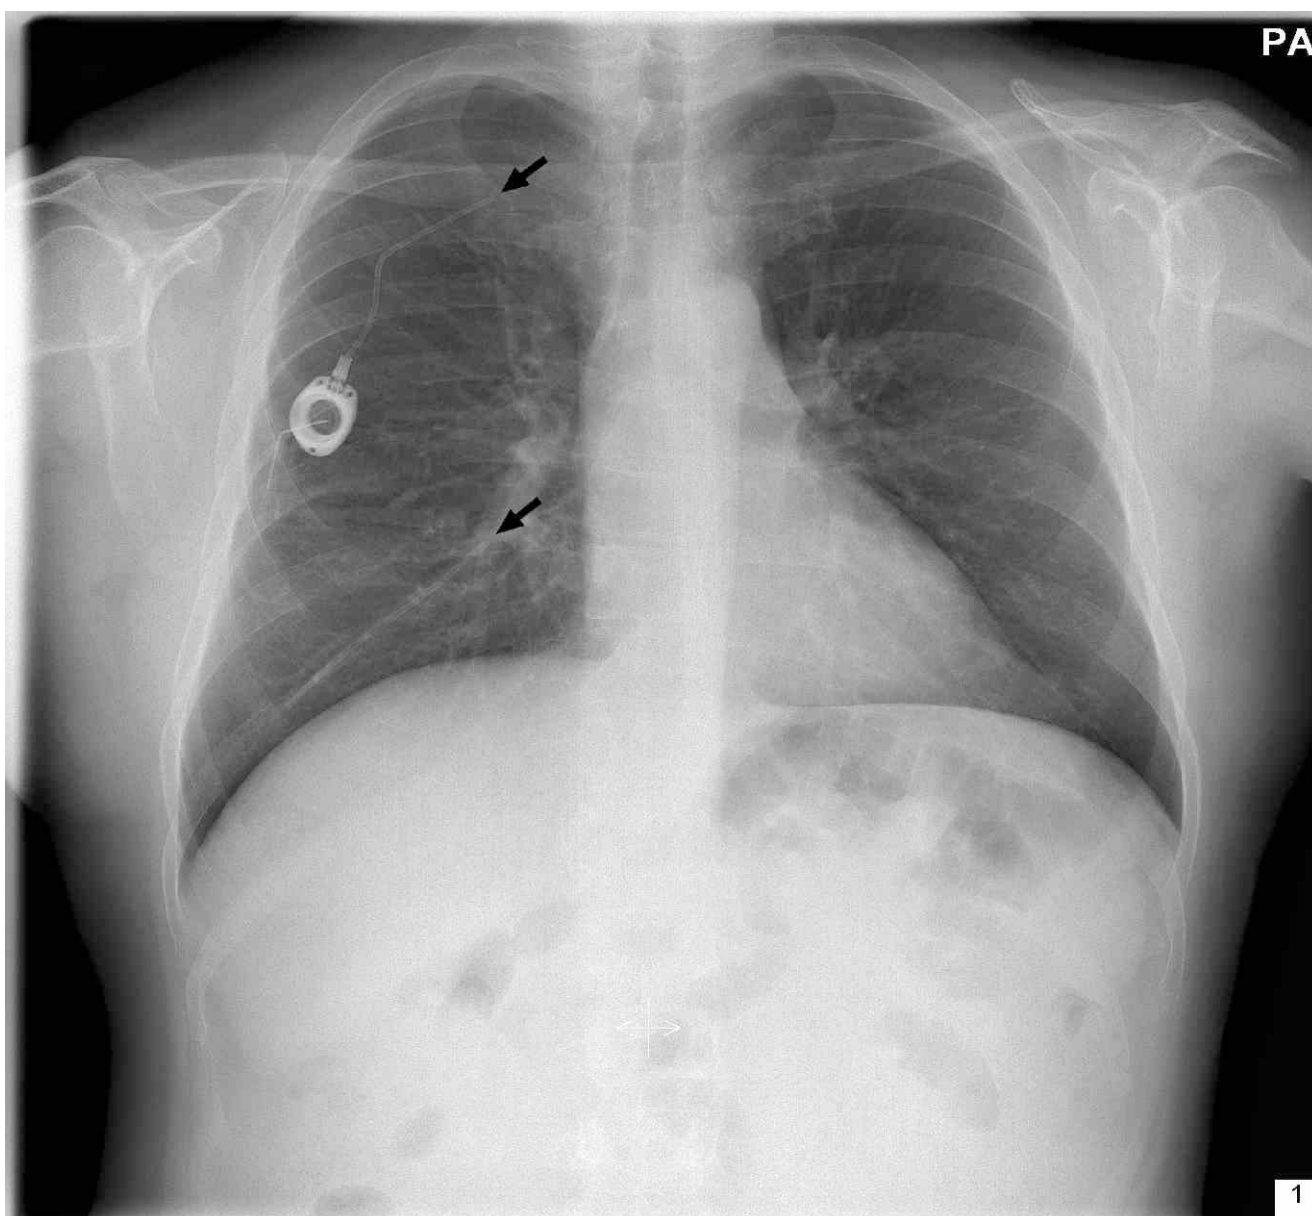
The chest x-ray image clearly shows the proximal tract of the catheter connected to the chamber and the big distal fragment in the right lung lower lobe.
